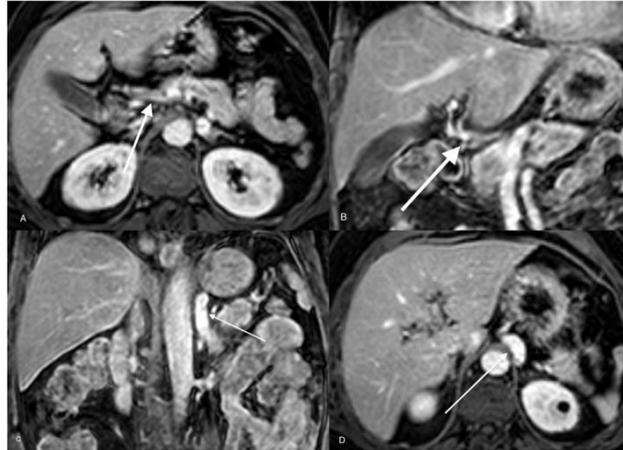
Abdominal MRI performed during the initial workup. T1-weighted imaging post-contrast shows a hypoplastic portal vein (A and B, arrows). Vascular structure is shown communicating the portal vein to the left renal vein (C and D arrows).
